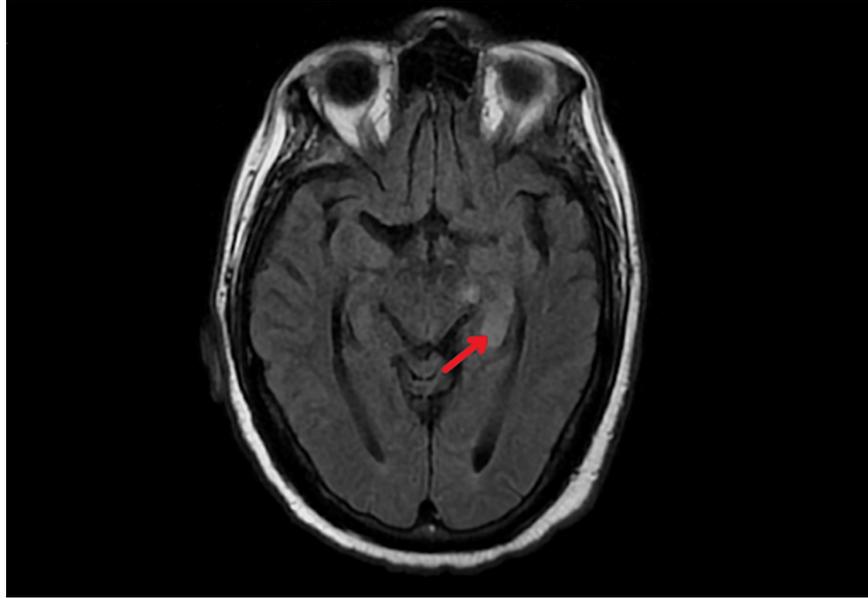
T2-weighted MRI Brain. Red arrow indicates area of subacute infarct in the left temporal lobe of the brain.
